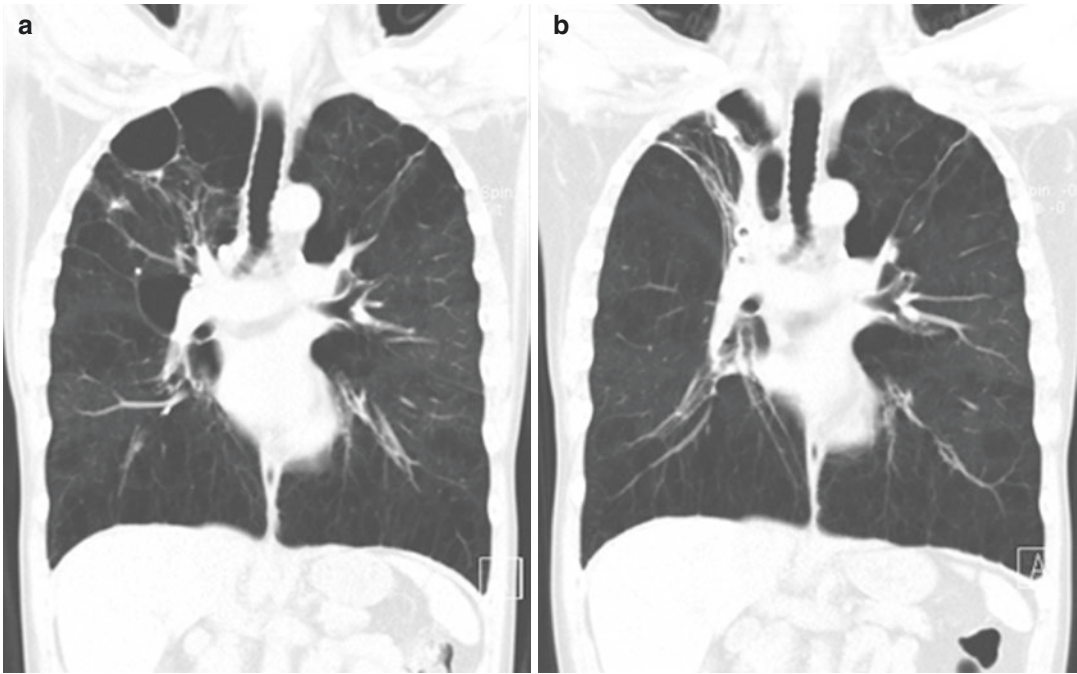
Effect of lung volume reduction procedure. (a) CT image in a 61-year-old male showed severe and regional heterogeneity of emphysema. Endobronchial L was performed to collapse the RUL which was most
